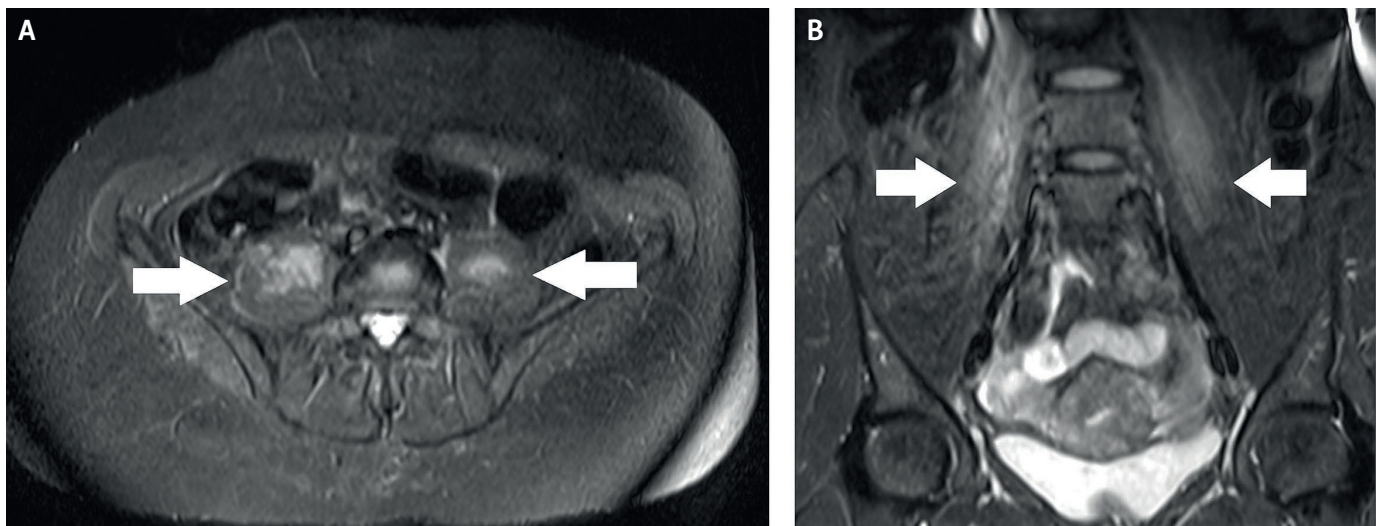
T2 FAT SAT MRI in axial section (A) and coronal section (B) shows significant edema in the psoas major muscle bilaterally (white arrows), more pronounced on the right side, consistent with delayed-onset muscle soreness of the psoas major muscles.
